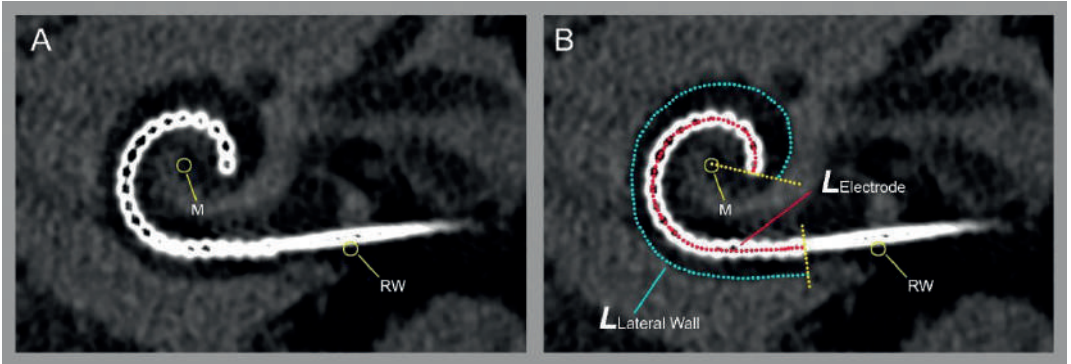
Method for measuring the wrapping factor (WF) on a multiplanar reconstruction along the basal turn of the cochlea (A and B) in an ultra-high-resolution computed tomography (UHR-CT) scan. WF was defined as the proximity of the electrode array relative to the modiolus, and was calculated and compared only in participants with a ST-located CI [10]. WF is calculated as: $WF = \frac{LElectrode}{LLateral\ Wall}$. The length of the lateral wall ($LLateral\ Wall$) and the length of the electrode ($LElectrode$) were measured (in millimeters) by first defining the center of the round window (RW) and the modiolus (M). Then, two lines were drawn; one to indicate the onset, a “starting point line” perpendicular to the first contacts on the electrode, and the “end point line”, drawn between the modiolus (M) and the contact located at 360° or, if below 360°, the most apical contact. This resulted in a score between 0 and 1, with 0 indicating the closest possible proximity to the modiolus and 1 reflecting the closest possible proximity to the lateral wall of the cochlea.
